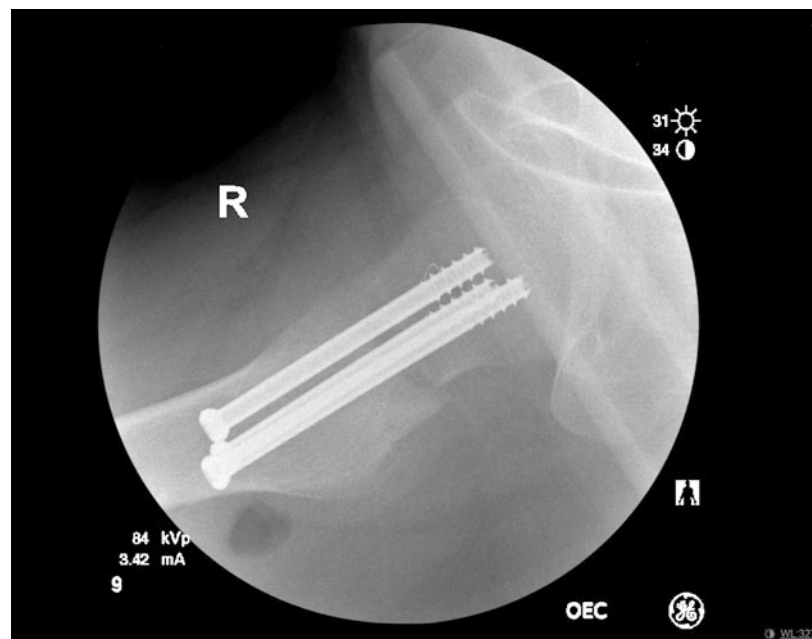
Lateral radiograph of the right hip demonstrating satisfactory alignment of the fracture with screws outside proximal femoral physis
